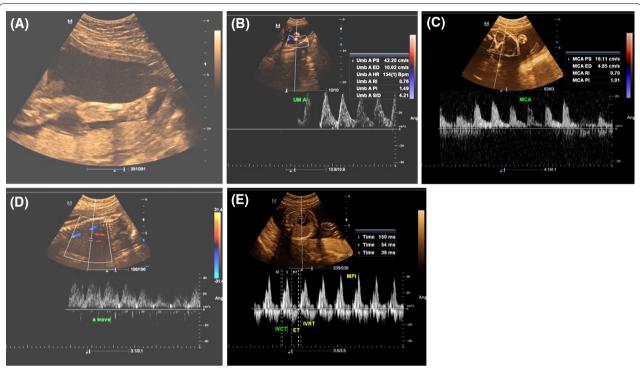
A 28-year-old primigravida patient, was examined at 34 weeks gestation, had an US foetal age of 31 weeks and foetal weight of 1860 gm. A US showing marked turbidity of amniotic fluid (Meconium). B Doppler US of umbilical artery showing increased pulsatility index. C Colour Doppler assessment of middle cerebral artery (MCA) in a growth-restricted foetus showing high diastolic velocities and decreased pulsatility index. D US Doppler spectrum of foetal DV showing reversed a wave. E Doppler trace of isovolumetric contraction time, ejection time, isovolumetric relaxation time for assessment of left ventricular MPI
